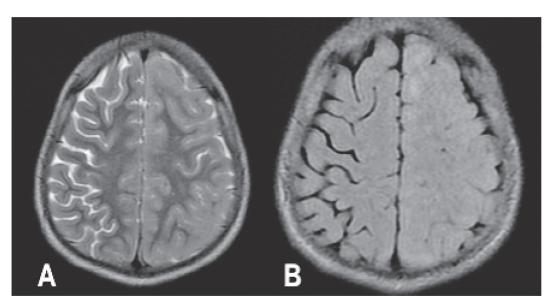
Cerebral MRI of the patient. A - SE / T2 sequence; B - FLAIR sequence
